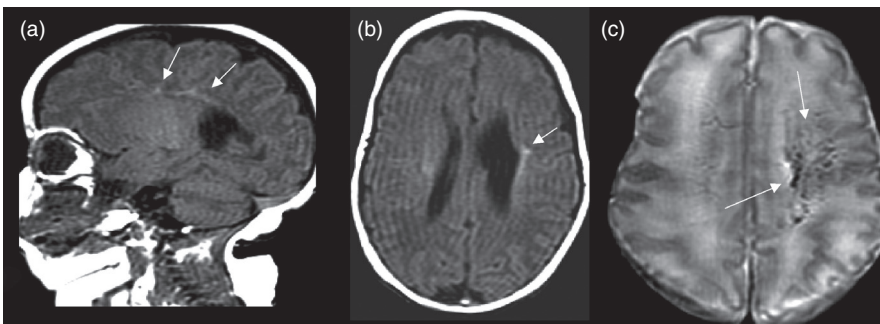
Non-cystic PVL with foci of gliosis (arrows) as high intensities on (a) sagittal and (b) axial T1 MRI, plus mineralization or hemorrhages (arrows) as low intensities on (c) axial GRE MRI.
